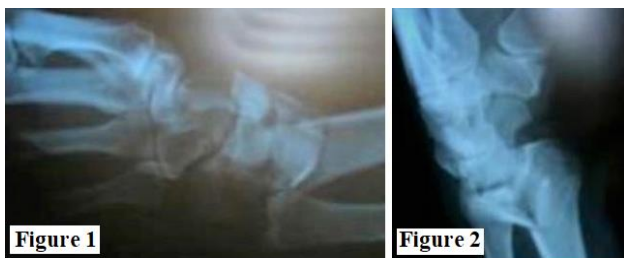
Preoperative Anterior-posterior X-ray
